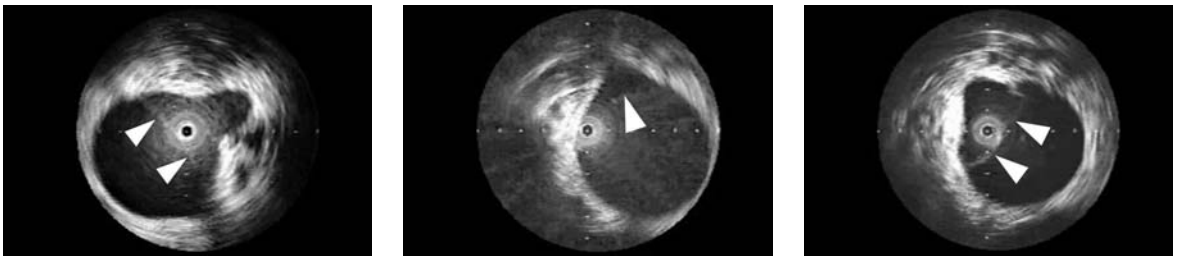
A patient with acute type B dissection was being evaluated for renal artery involvement. Intravascular ultrasound (a) of 90/50 showed a capacious true lumen with unimpeded SMA perfusion. During treatment for impending sedation-induced
